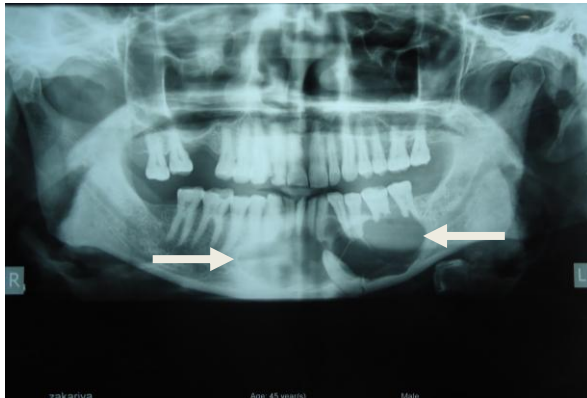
Panoramic radiograph reveals a well defined hazy radioluscent lesion with superior scalloped margin with an evidence of resorption and displacement of teeth and an impacted tooth
